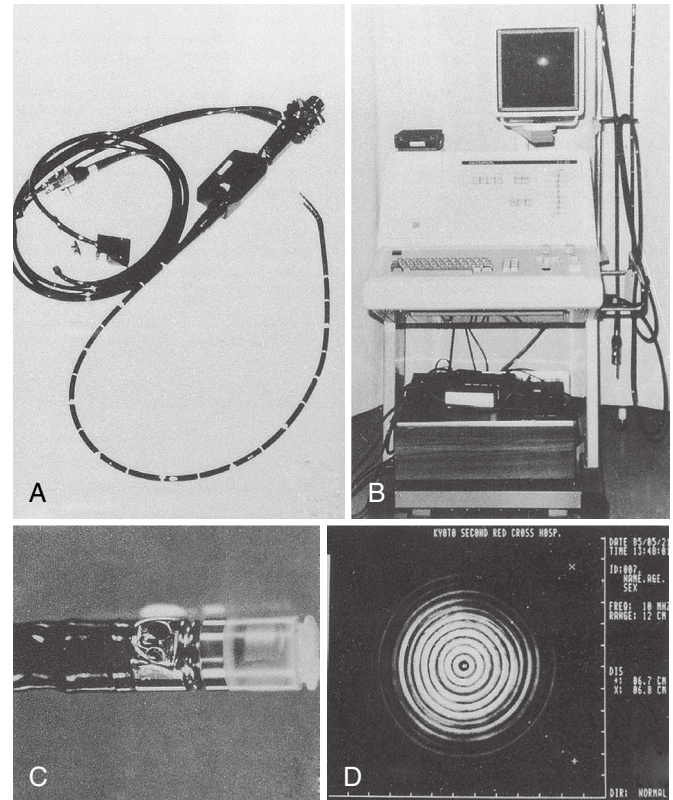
A to D, Ultrasonic endoscope system, model IV, made by Olympus Corp., 1986. (From Yasuda K, Mukai H, Fujimoto S, et al: The diagnosis of pancreatic cancer by endoscopic ultrasonography. *Gastrointest Endosc* 34:1–8, 1988.)
